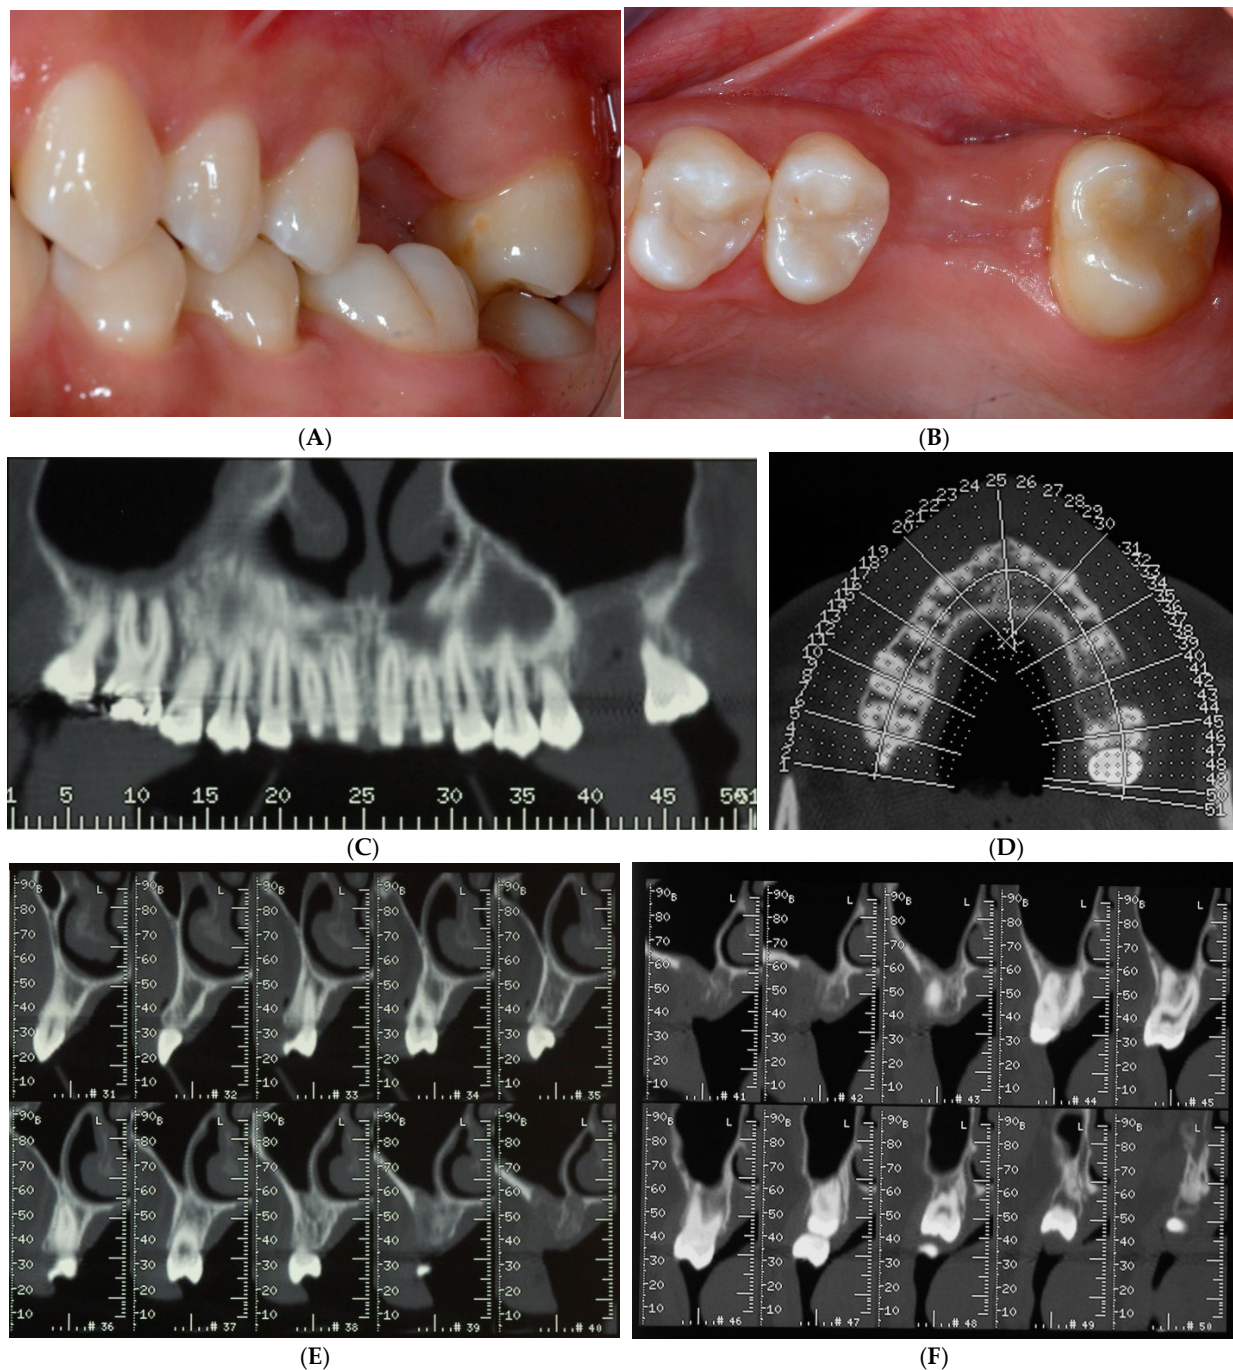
Soft tissue healing four months after tooth extraction (A,B). New CT was requested to evaluate wound healing and current bone availability for implant therapy. CT scans revealed horizontal ridge defect (C–F) that had to be corrected with a regenerative procedure.
